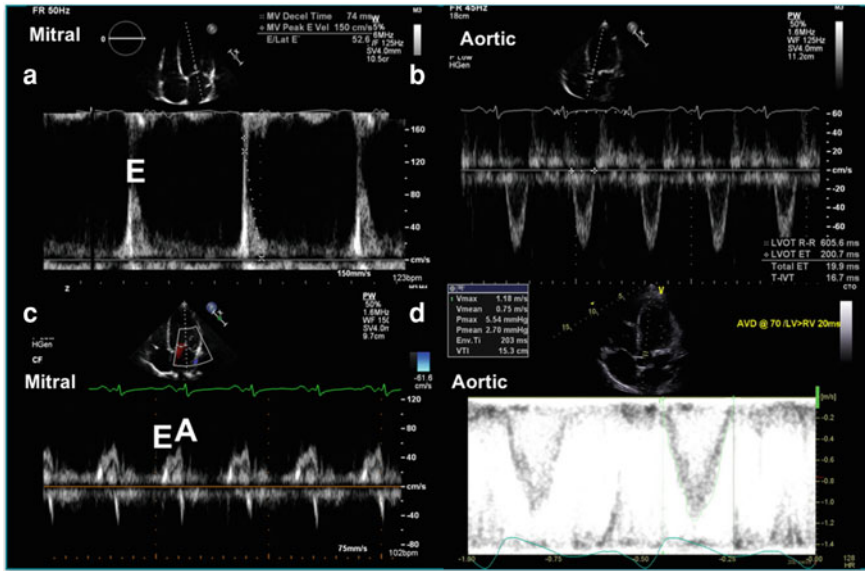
Echocardiography-guided pacing optimization on the intensive care unit. Pacing optimisation to improve cardiac output in a patient with significant electromechanical dyssynchrony (the same patient as shown in Fig. 8.4), after biventricular pacemaker insertion, but before pacing optimisation. Upper panel, pre-optimisation: a transmitral PW Doppler showing an isolated E wave with a high velocity short deceleration time consistent with restrictive LV function and a high left atrial filling pressure. b Biventricular pacing has reduced the tIVT to 16.7 s. Lower panel, post-optimisation. Systematic alteration of heart rate, AV delay and VV delay has improved the electromechanics of the patient. c transmitral PW Doppler now demonstrates both E and A waves on transmitral filling. The tIVT has been reduced, and the aortic VTI increased to 15.3 cm. Pacing optimisation settings are shown in yellow: AV delay 70 ms and LV-RV delay 20 ms. PW; pulse wave, E; early transmitral filling, A; late transmitral filling, tIVT; total isovolumic time, LV; left ventricle, AV; atrio-ventricular, VV; ventriculo-ventricular, RV; right ventricle
